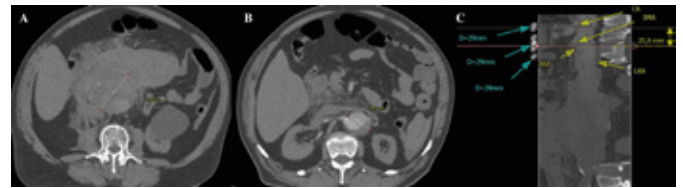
A, B. Computed tomography angiography depicting a ruptured pararenal aneurysm with a 72mm maximum diameter and an infrarenal neck 40mm in diameter. C. Center lumen line showing the distances between the three target vessels for planning a 3x chEVAR.
